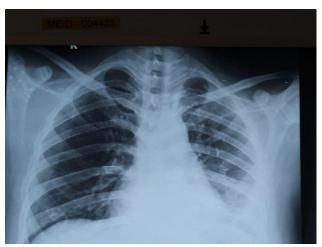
Chest radiograph after 2 weeks of discharge.
